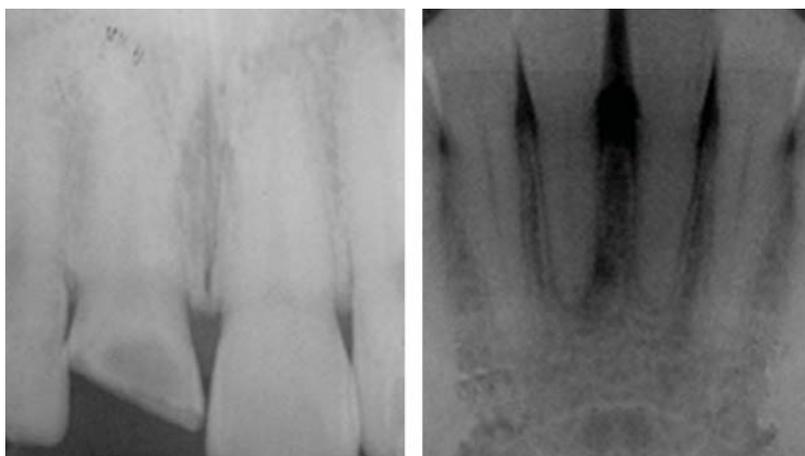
Preoperative periapical radiographs of (A) maxillary right central incisor and (B) mandibular right central incisor.
